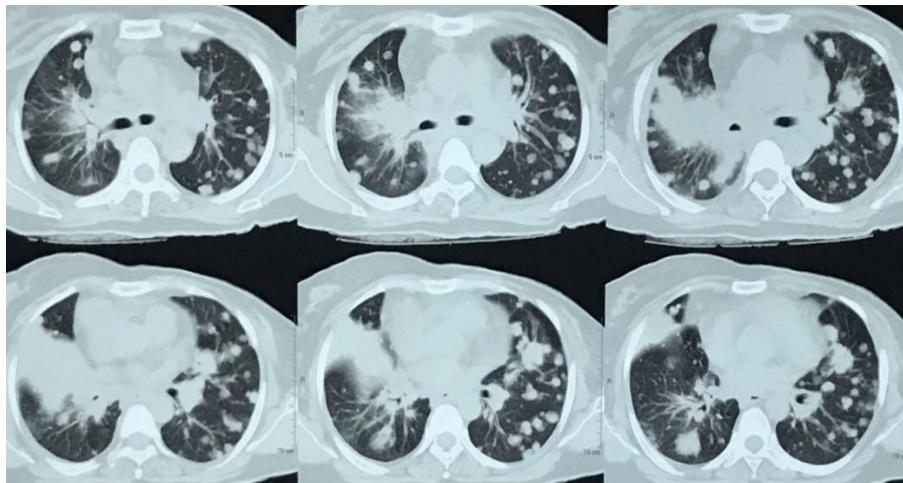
HRCT thorax showing bilateral cannon ball opacities with central parenchymal opacities suggestive of metastatic lung disease
